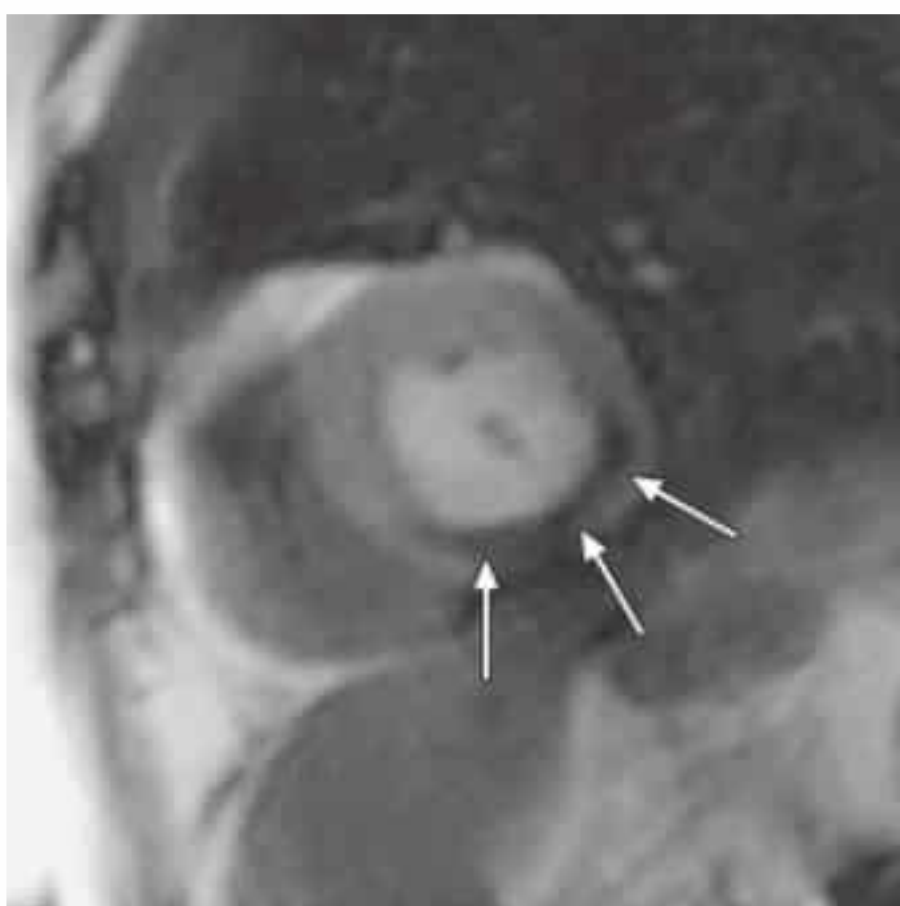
Detection of ischemia by perfusion MRI with adenosine stress. Apical short-axis slice of the LV acquired with a saturation-recovery SSFP sequence (one image per heart beat in each of four short-axis planes) clearly demonstrates a hypointense stripe in the subendocardial layers of the inferior wall (arrows, AHA segment 15) with septal and lateral extension. The cause is a high-grade stenosis of the RCA.
